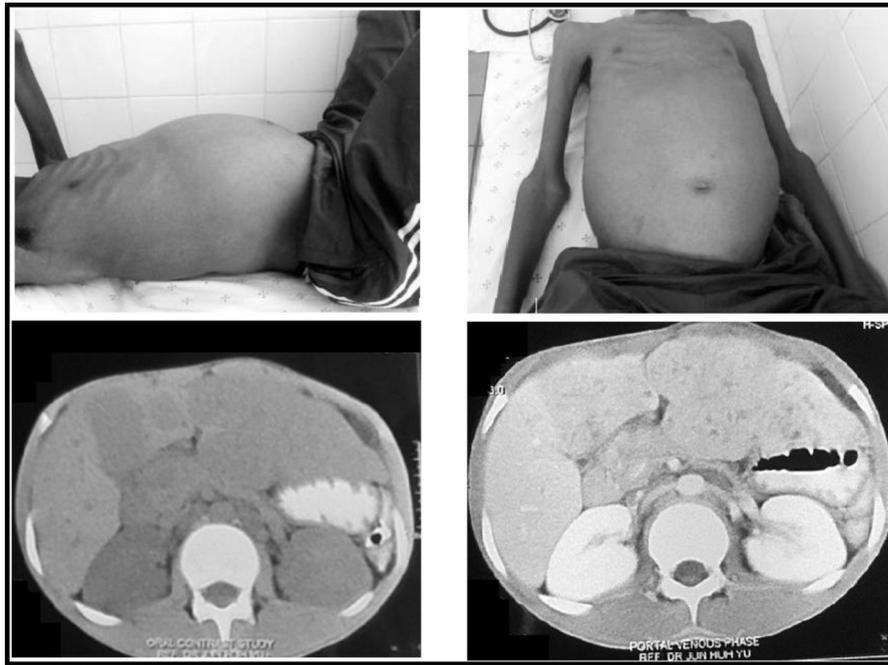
Subject of Multidisciplinary Tumor Board. 20-year old man presenting with weight loss, vomiting, abdominal pain and distension, with a diagnosis of hepatocellular carcinoma. Computed tomography showing multinodulated masses within the left lobe of the liver and hilum, with dilated intrahepatic biliary ramifications in the region of the caudate and left lobes.
